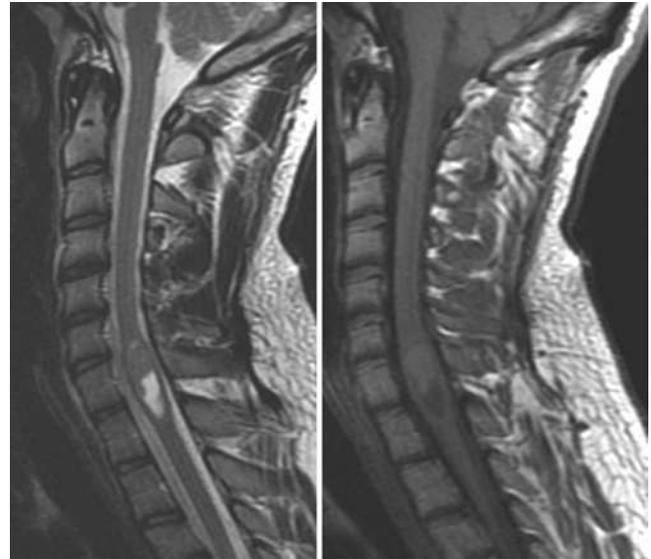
Case 19. Sagittal T2-weighted (left) and T1-weighted (right) MR images showing an incidental intramedullary mass lesion (assumed diagnosis of LGG) in a 12-year-old boy who was found to have a vertebral fusion anomaly.
